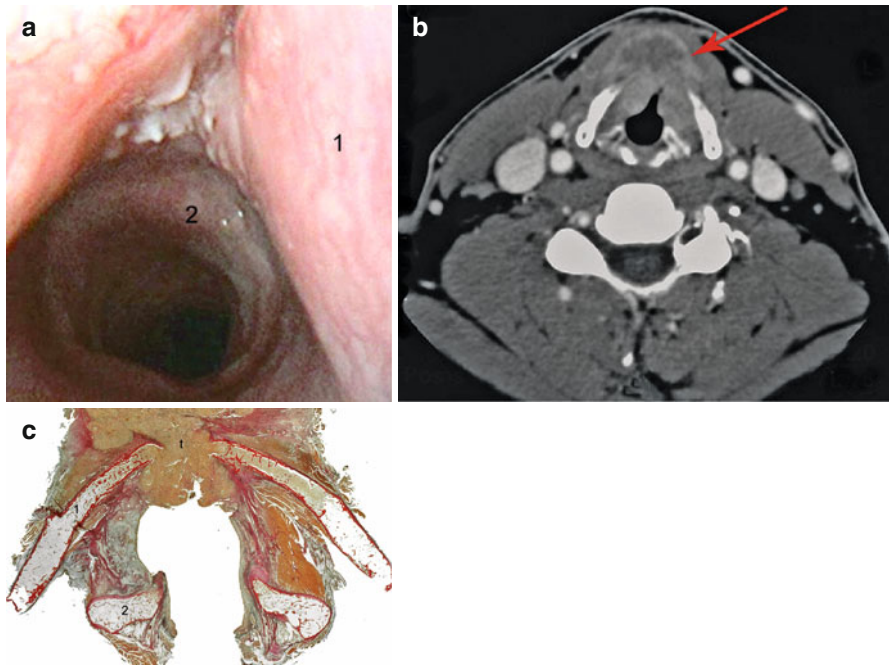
Carcinoma of the anterior commissure, with subglottic extension. (a) On video laryngoscopy the lesion is apparently superficial. 1 Right vocal cord, 2 first tracheal ring. (b) the CT shows a massive anterior extension through the cricothyroid space and the thyroid cartilage (arrow). (c) the macrosection, taken on a more cranial plane, shows the same details. 1 Thyroid cartilage, 2 arytenoid cartilage, t tumor through thyroid cartilage
